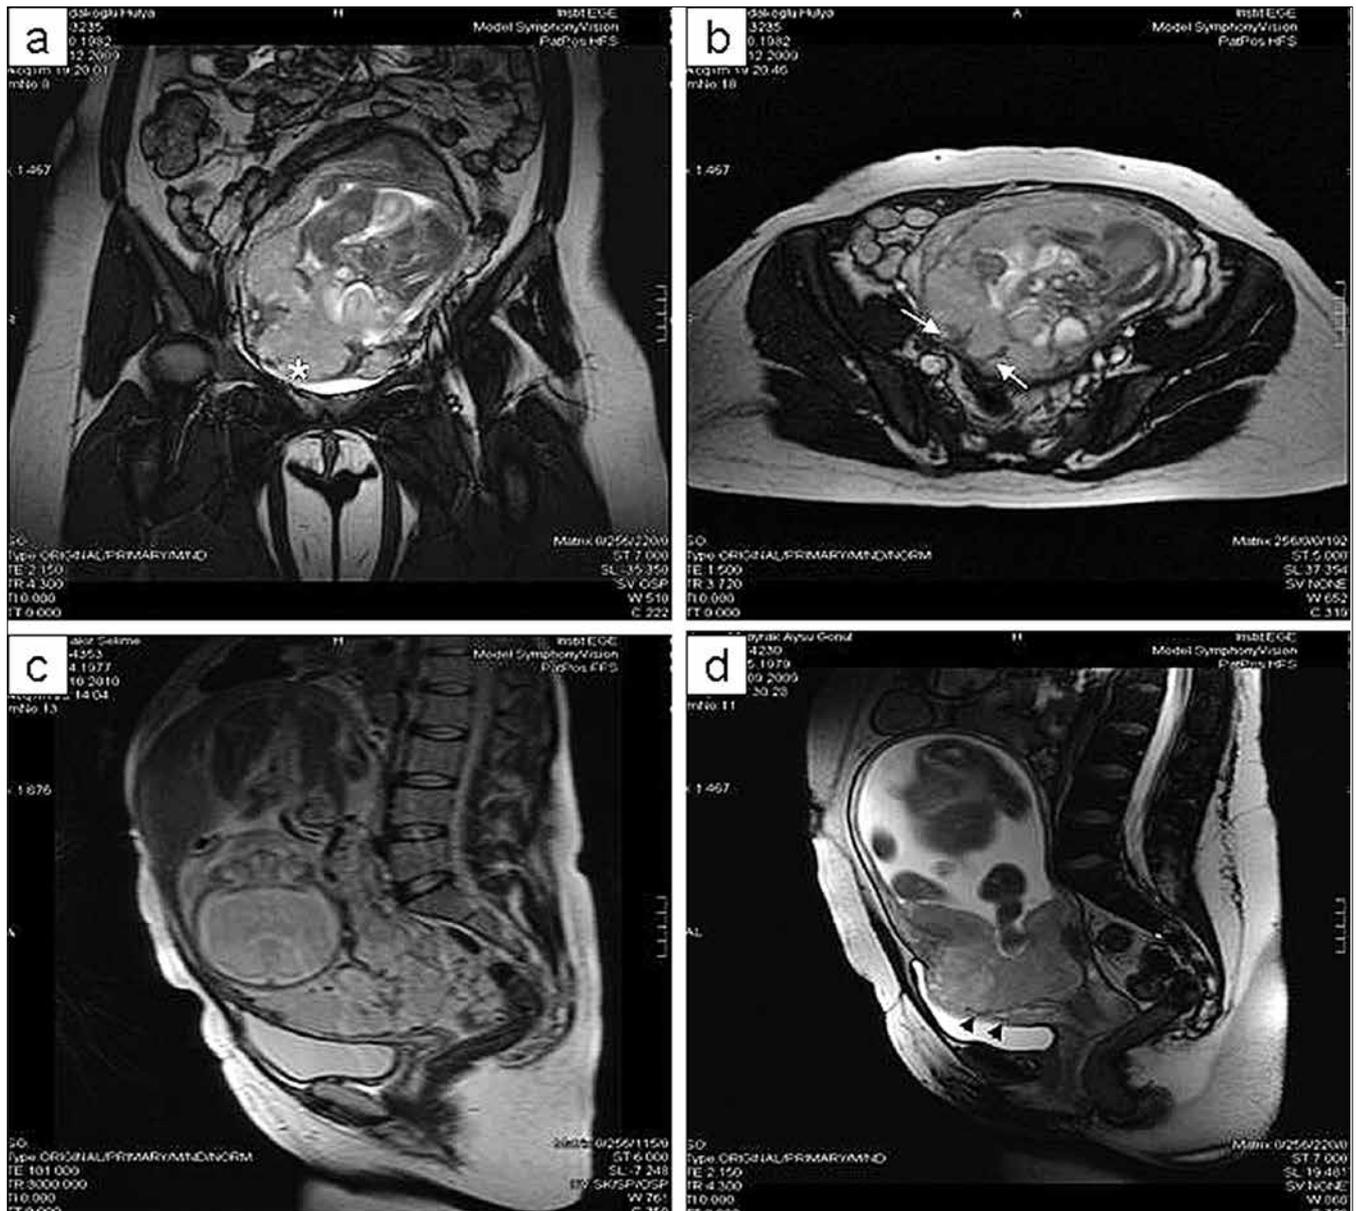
Abnormal uterine bulging (*) on the coronal true-FISP image (a). Dark intraplacental bands (arrows) on the axial true-FISP image (b), heterogeneous signal intensity within the placenta on T2-weighted sagittal image (c), loss of the tissue plan between the placenta and bladder wall (arrows) on the sagittal image (True-FISP image).
